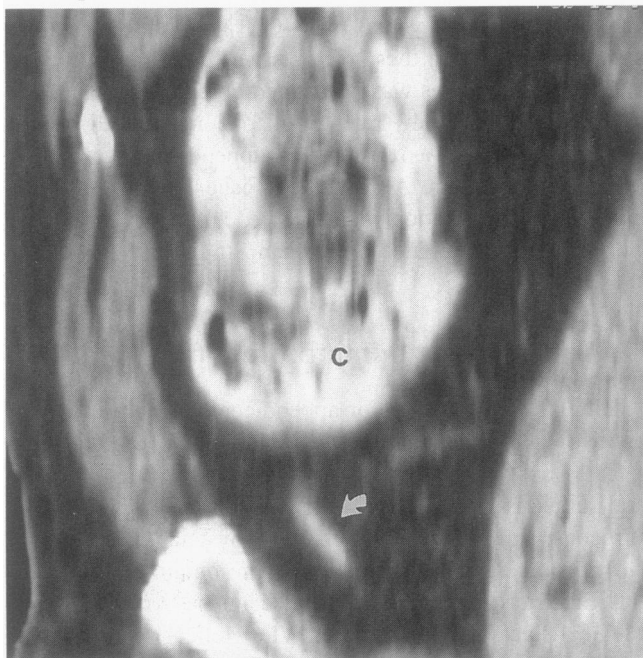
Coronally reformatted CT image of a 64-year-old man with a patent lumen, normal appendix (*arrow*) caudal to the cecum (C).
